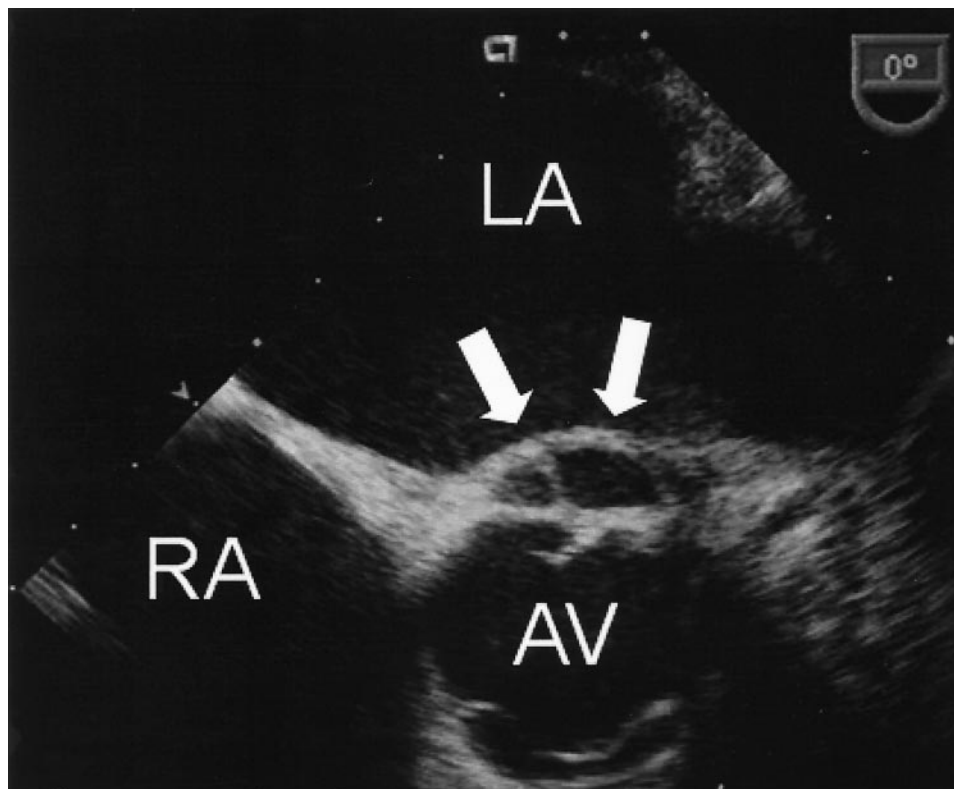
Transesophageal echocardiogram of paraprosthetic abscess. Extending from the mitral bioprosthetic ring and adjacent to the native aortic valve (AV) there is a septated echo-free space (arrows), a finding indicative of abscess formation. LA, left atrium; RA, right atrium.
